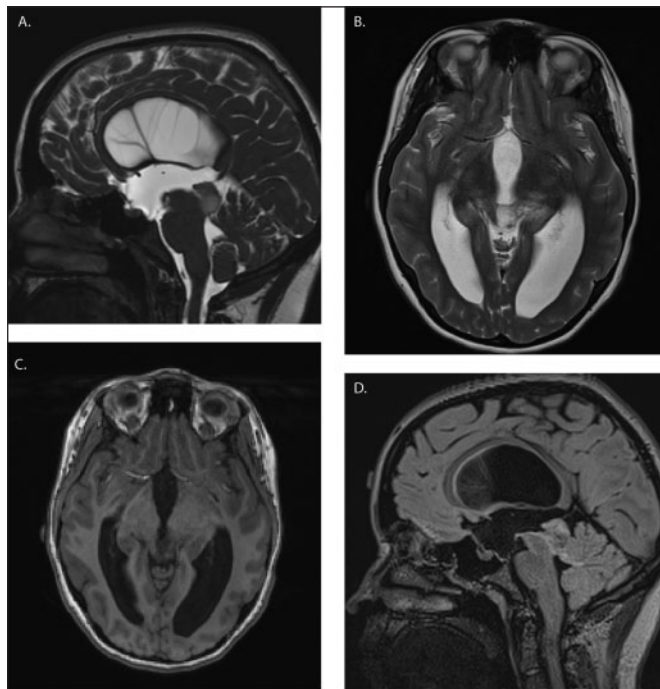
MRI appearance of a tectal glioma. A) T2-weighted sagittal MRI showing a hyper-intense lesion in the tectal plate causing obstructive hydrocephalus. B) T2-weighted axial MRI of the same lesion. C) T1-weighted axial MRI showing a hypo-intense lesion in the superior colliculus. D) FLAIR MRI showing heterogeneous signal surrounding and within the lesion.
